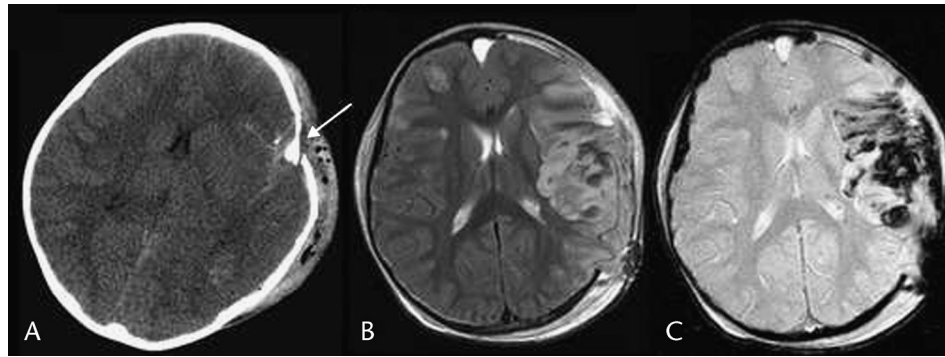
Traumatic injury in a 2-year-old boy struck by a car. A, Noncontrast CT shows left depressed skull fractures (white arrow), frontal and temporal cerebral edema with loss of gray-white matter differentiation, hemorrhages, and mass effect (posttraumatic infarction or contusion). A left hemicraniectomy was done for impending herniation. Postcraniectomy axial T2 (B) and GRE (C) images show increased hemorrhage and gyral swelling mainly in the left MCA distribution with transcranial herniation. This is more consistent with infarction than with contusion.
